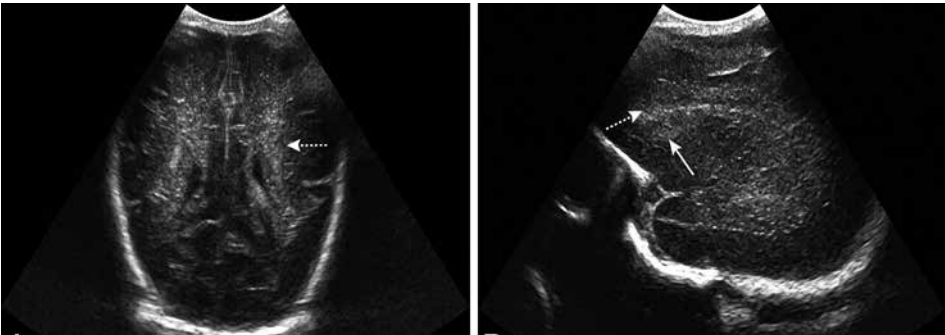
(A) Coronal and (B) parasagittal ultrasound scan in very preterm infant (gestational age 27 wk), showing subtle, homogeneously increased echogenicity in the frontal and parietal white matter (dotted arrows). Also showing mild, subtle echogenicity in the head of the caudate nucleus (arrow) in (B).
